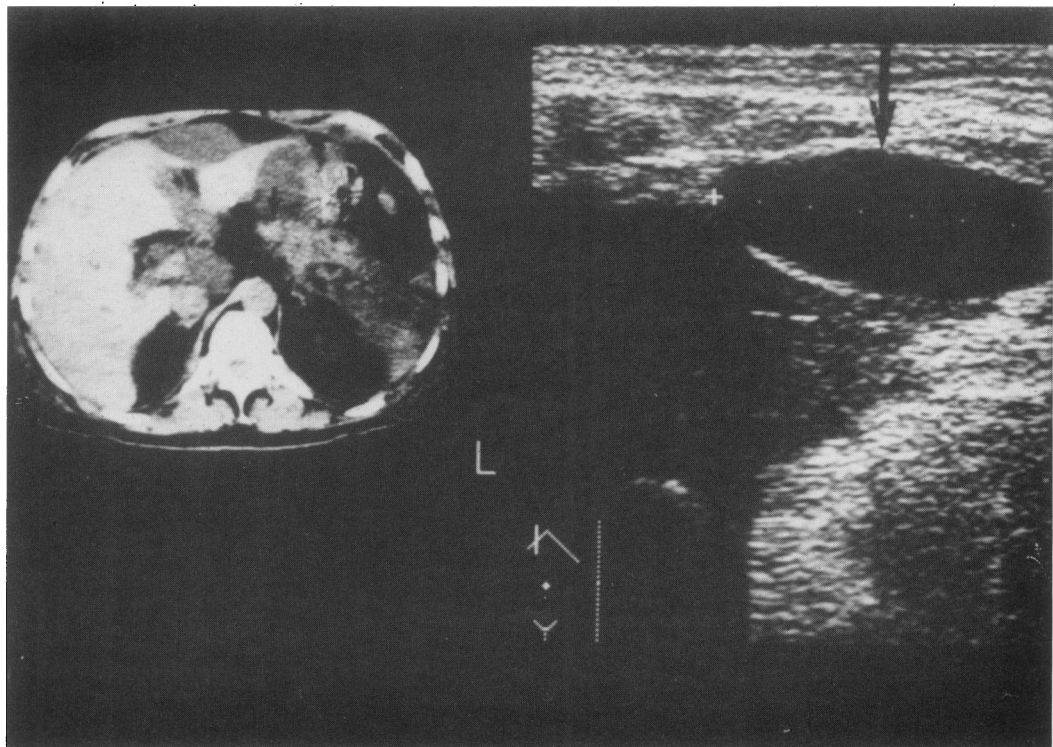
Left.* CT 10 days after Whipple procedure. Arrows point at edematous pancreatic remnant. *Right.* Ultrasound of same patient demonstrates subfascial fluid collection.
